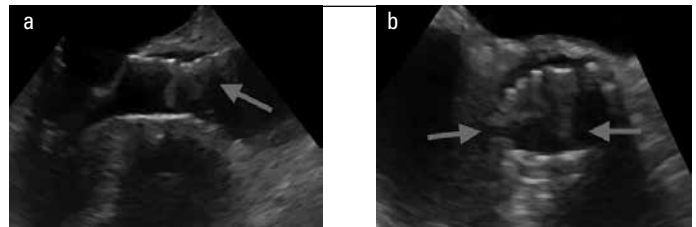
Transesophageal echocardiography showing a mass (18x7mm) on the CoreValve® prosthesis (white arrows). a) long-axis view; b) short-axis view
